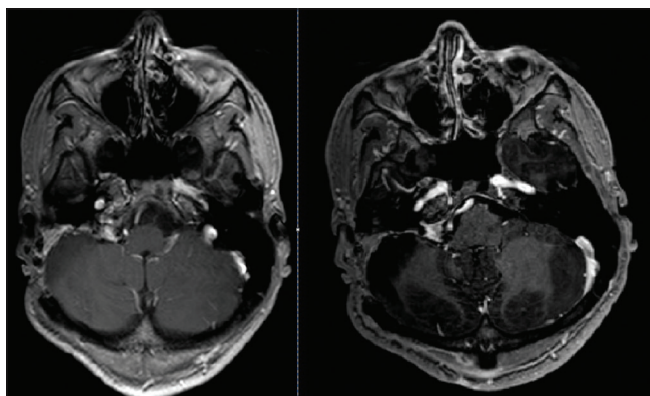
Postoperative contrast enhanced magnetic resonance imaging
